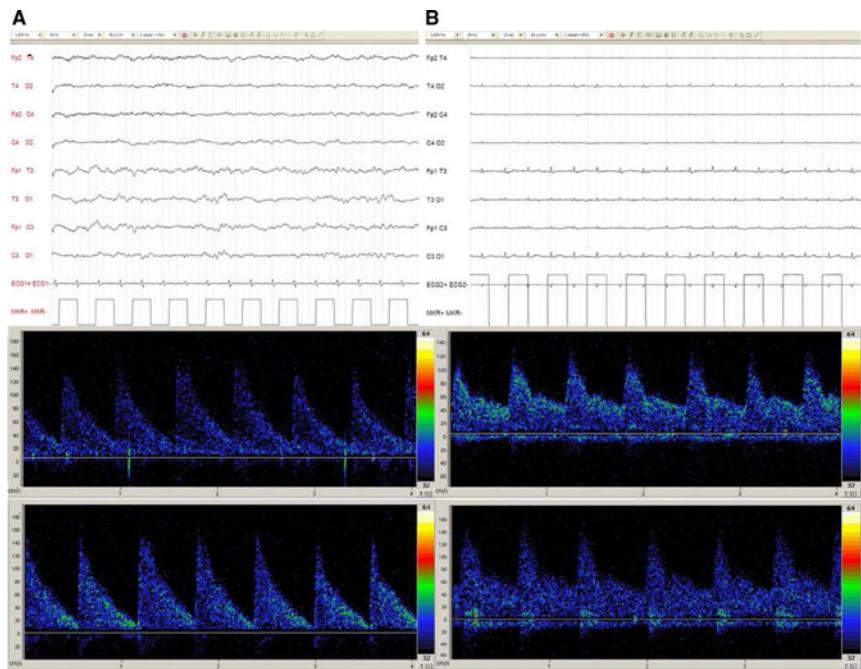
EEG (top) and transcranial Doppler (TCD) findings (below), before (a) and after (b) decompressive craniectomy in case 3. EEG before craniectomy shows the presence of a diffuse slowing of the background activity, predominantly on the right side and, after skull fenestration and sedation withdrawal, the disappearance of electrical activity. TCD before the craniectomy (a) shows a marked increase in the resistive indices with a diastolic component reduction and spectrum deformation, suggestive of increased intracranial hypertension. After decompressive surgery (b), diastolic flow velocity increases and resistive indices return to normal, but with flat EEG
